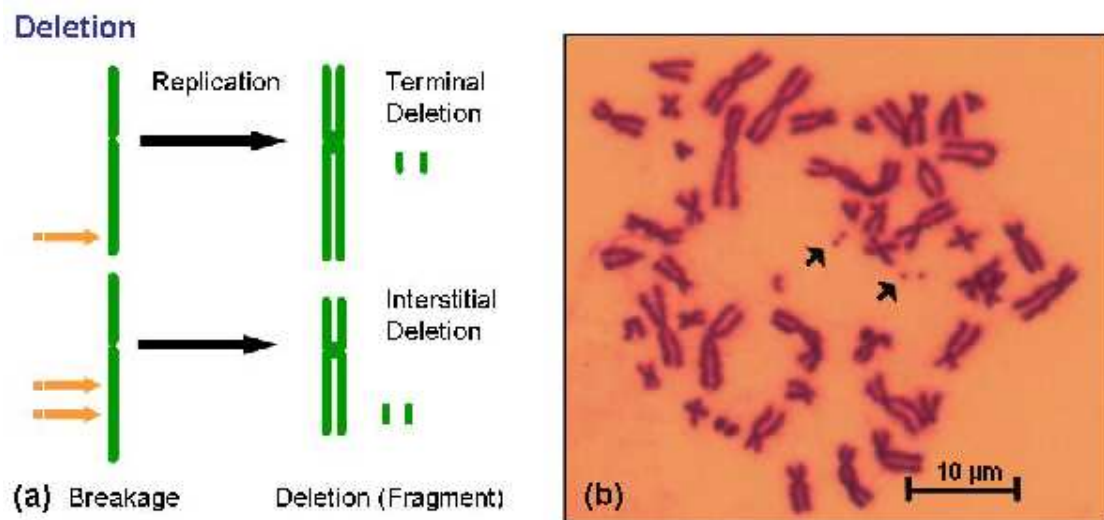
Chromosomal deletions a) Classification [54]; b) Excess fragments (arrows) observed in cell line 184A1 irradiated with a dose of 3 Gy of 10 kV soft X-rays.
